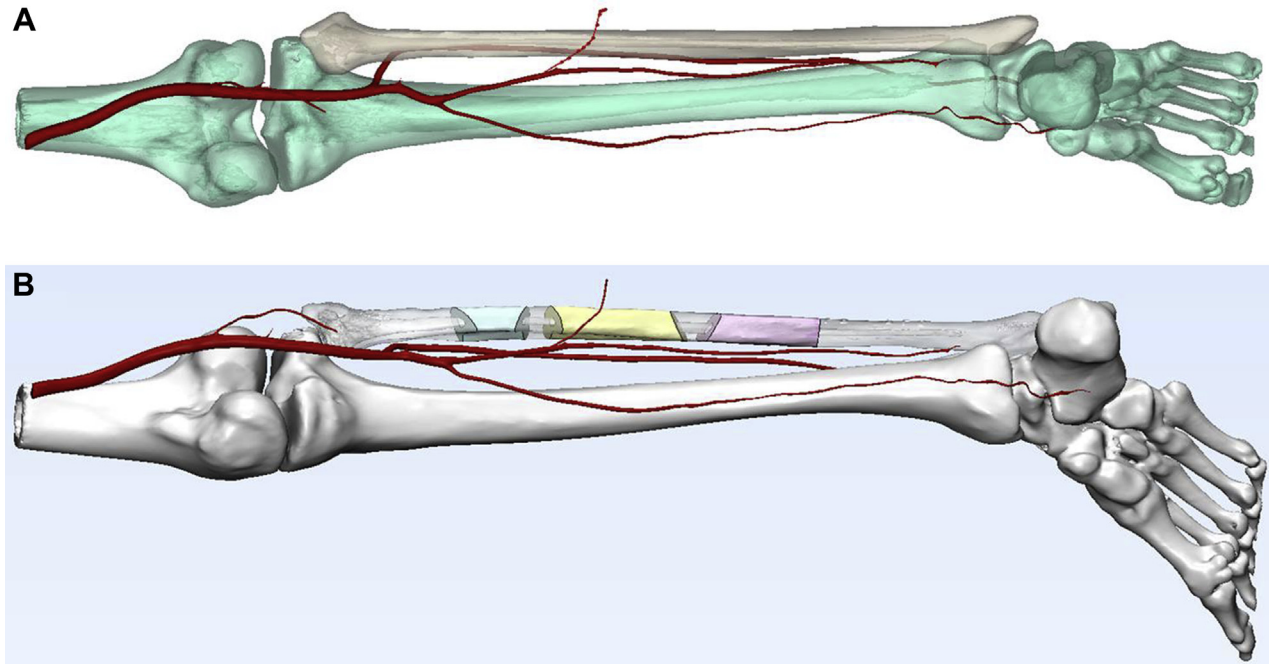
Three-dimensional rendering of the perforator trajectory based on the surgeon-directed computed tomographic angiography tracing. *A*, Posterior view displaying the path of the cutaneous perforator as it courses around the posterior aspect of the fibula to supply the skin of the lateral leg (note the oblique course of the perforator from the peroneal takeoff to its termination in the skin). *B*, Designed fibular osteotomy segments taking into account the cutaneous perforator takeoff and trajectory identified during the surgeon-directed computed tomographic angiography tracing.
